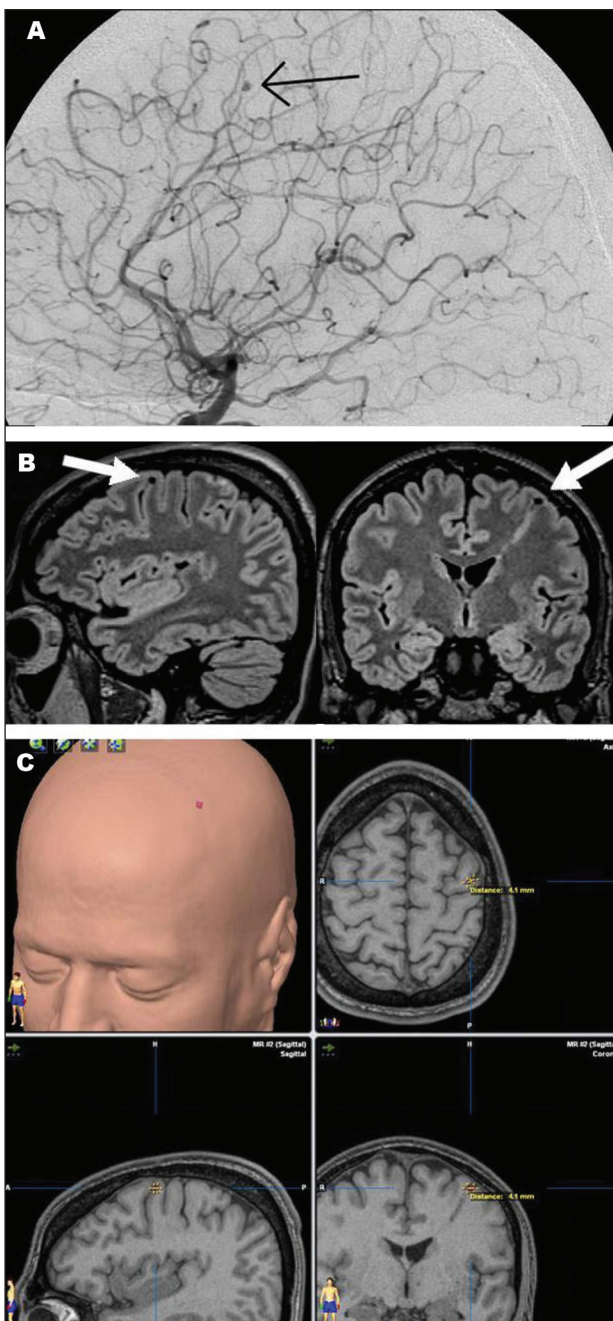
[A] Lateral carotid digital subtraction angiogram showing a saccular aneurysm (arrow) arising from a cortical branch of the left MCA. [B] Sagittal and coronal MRI T1WI based images showing a small round hypointense lesion measuring 4.1 mm with signal void (arrows) located cortico-subcortically near the left precentral sulcus. [C] Three-dimensional reconstructed images showing how BrainLab Navigation System was used for intraoperative localization of the aneurysm with preoperative MRI as a reference.
